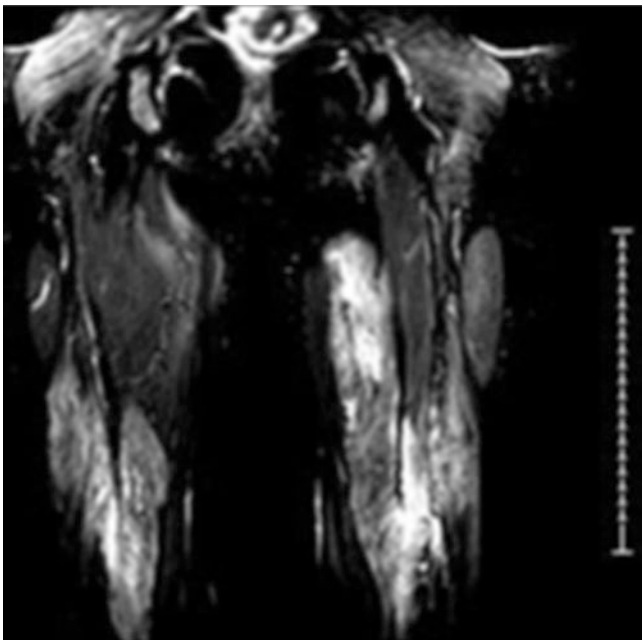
Magnetic resonance imaging (MRI) of muscle in polymyositis. Short T1 inversion recovery (STIR) MRI sequence of lower extremity muscles in a case of polymyositis demonstrates increased signal intensity consistent with inflammation and edema
